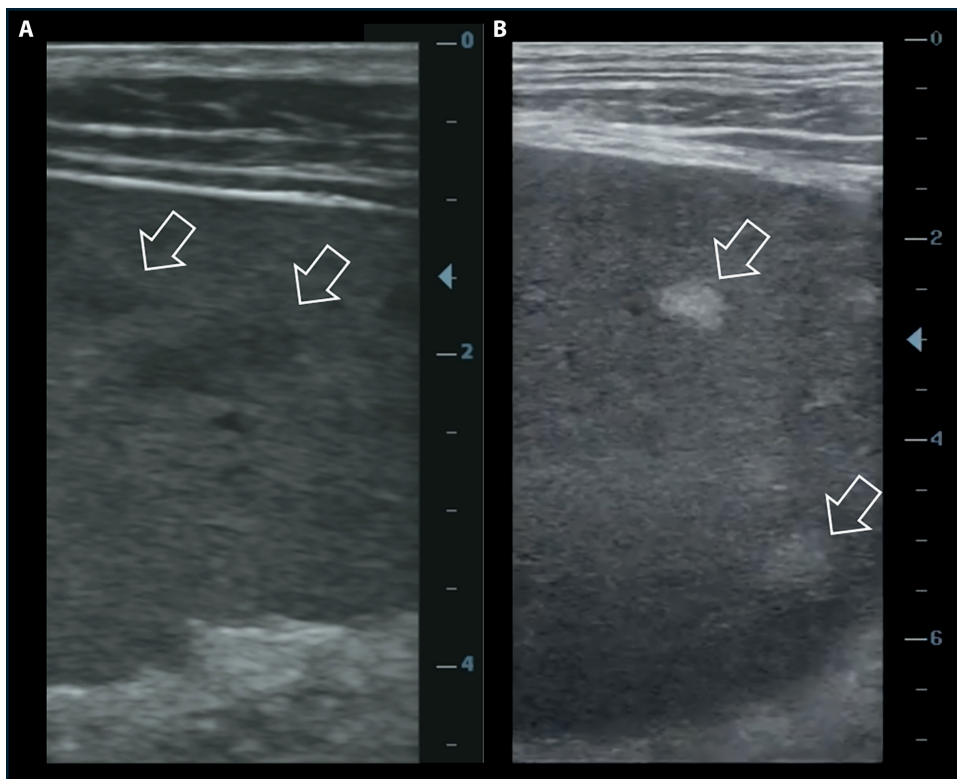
Sonographic appearance of focal lesions in the spleen. a) Hypochoic lesions seen in disseminated lymphoma and TB(26); b) Hyperechoic, hemangioma-like lesions suggestive of disseminated Kaposi's Sarcoma(30).
